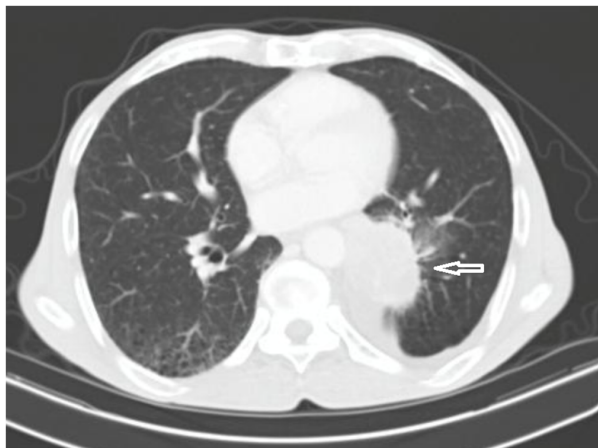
CT scan axial view showing left mass in the left lower lung lobe
